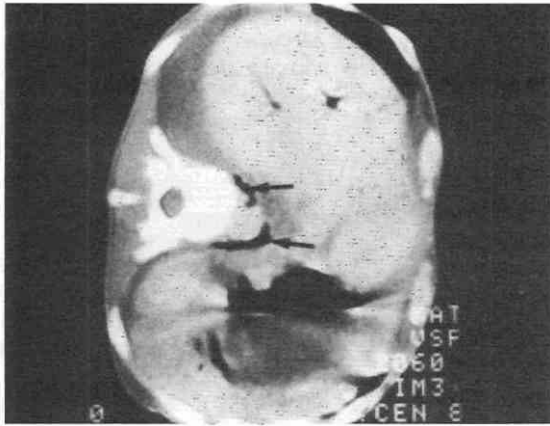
CT scan of a patient shows the air “marker” tracking into the chest (arrows) behind the crura. Injection should not be made in such cases, or mediastinitis may develop.
